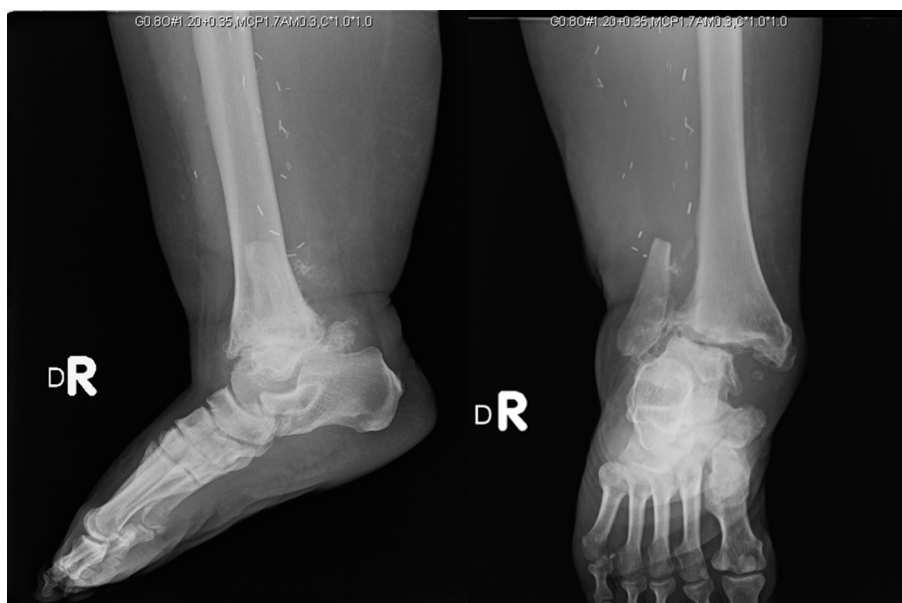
The right ankle plain film shows osteophytes formation, joint space narrowing, and ankle joint subluxation (11 months after free fibular flap surgery).
